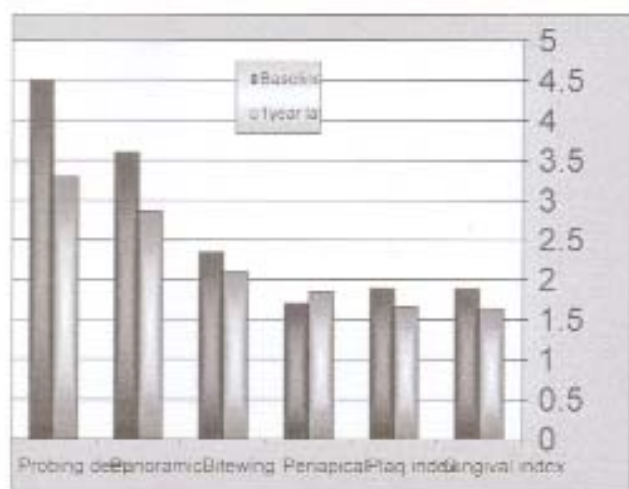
Changes in radiographic and clinical measurements.
